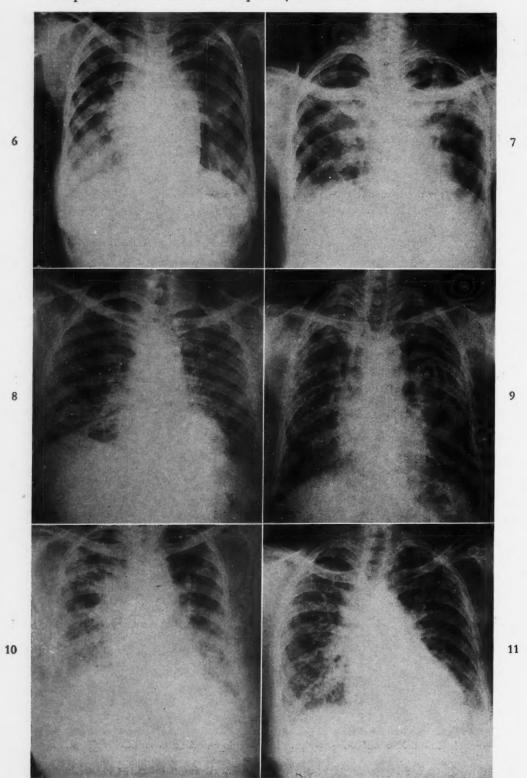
Case vi. X-ray of L. W.; Boeck's sarcoid with pulmonary involvement. Fig. 7. Case vii. X-ray of E. L.; pulmonary fibrosis; Boeck's sarcoid. Fig. 8. Case viii. X-ray of F. L.; pulmonary fibrosis; exposure to beryllium. Fig. 9. Case ix. X-ray of F. S.; undiagnosed disease of the lungs. Fig. 10. Case x. X-ray of E. M.; undiagnosed disease of the lungs. Fig. 11. Case xi. X-ray of M. H.; undiagnosed disease of the lungs.
